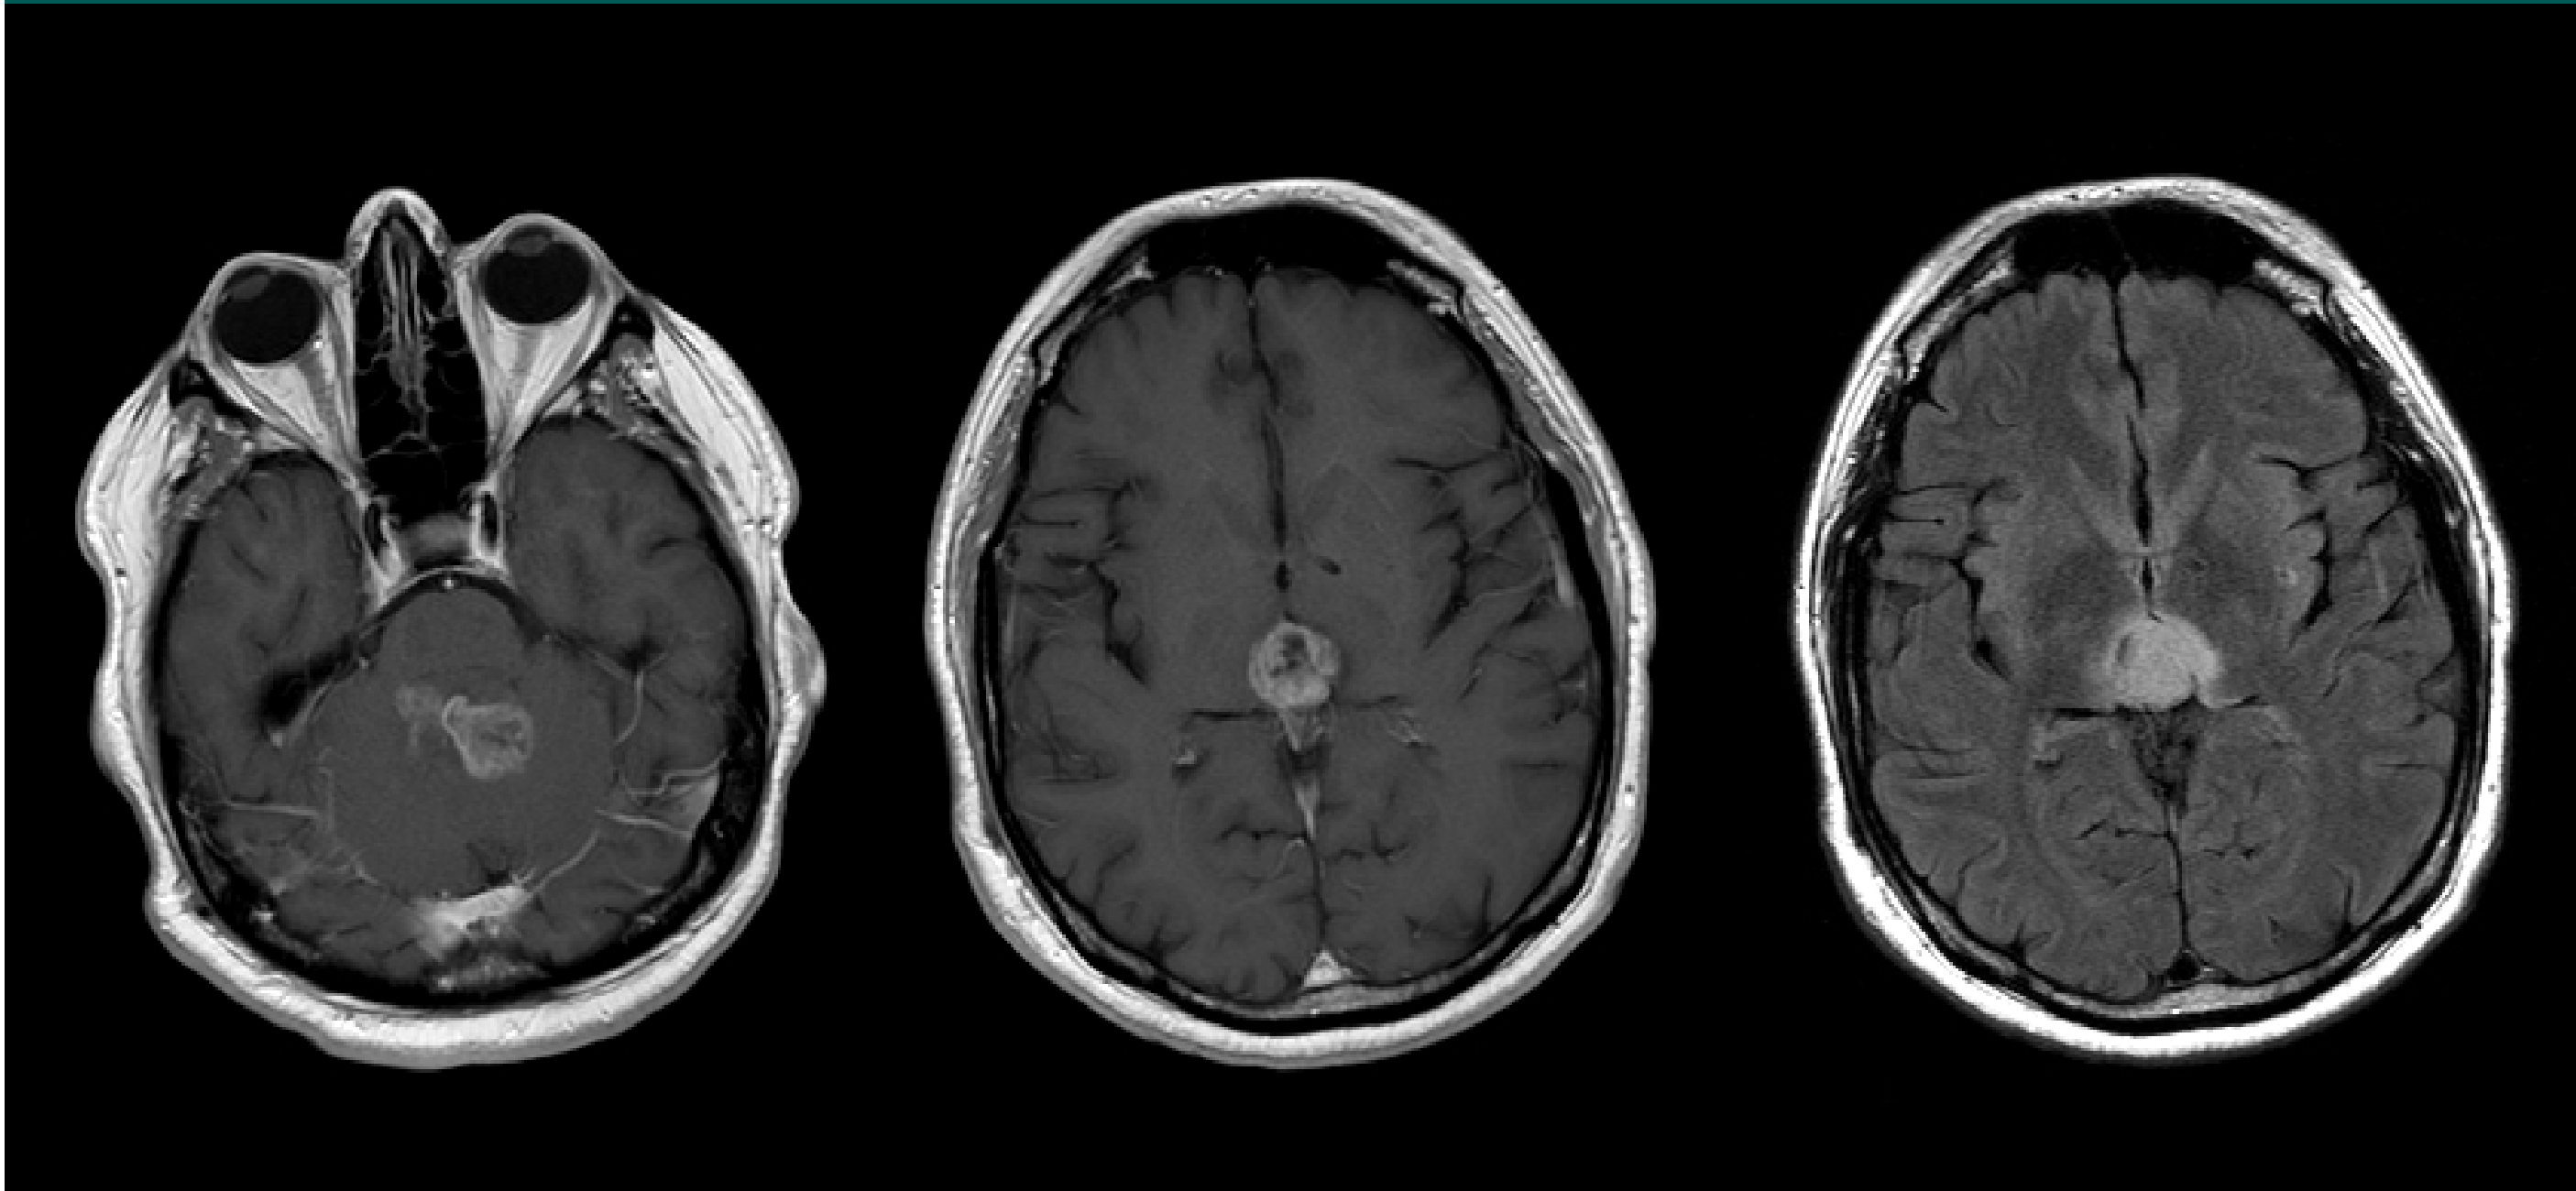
MRI head with and without contrast showing marked interval increase in size and abnormal enhancement of the mass in the region of the superior tectum and around the fourth ventricle consistent with progression.
